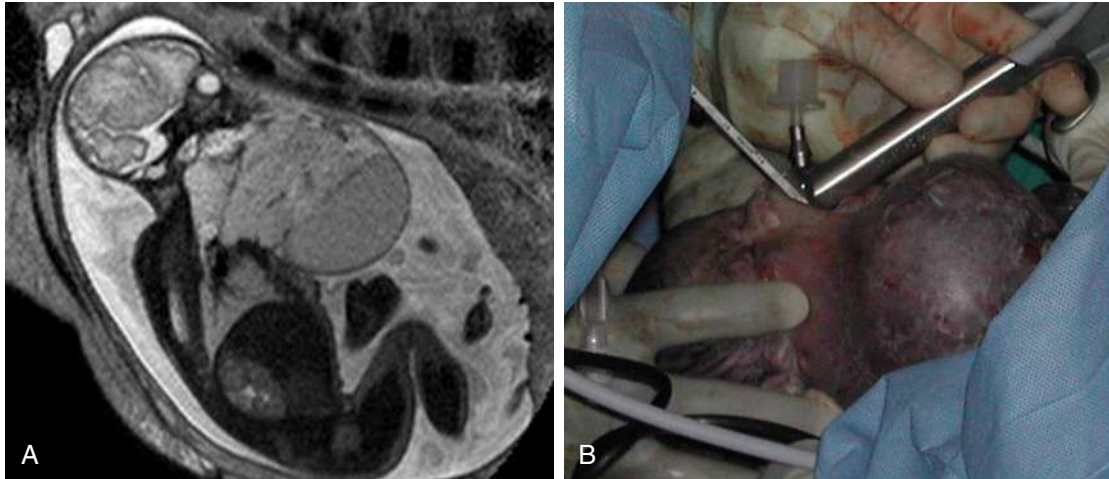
A, Ultrafast MRI of fetus with giant cervical teratoma showing polyhydramnios and hyperextension of the neck. B, Fetus with giant cervical teratoma at the time of intubation by direct laryngoscopy and rigid bronchoscopy. (From Lazar DA, Olutoye OO, Moise KJ, et al. Ex-utero intrapartum treatment procedure for giant neck masses – fetal and maternal outcomes. *J Pediatr Surg.* 2011;46:817–822, Fig. 1.)
